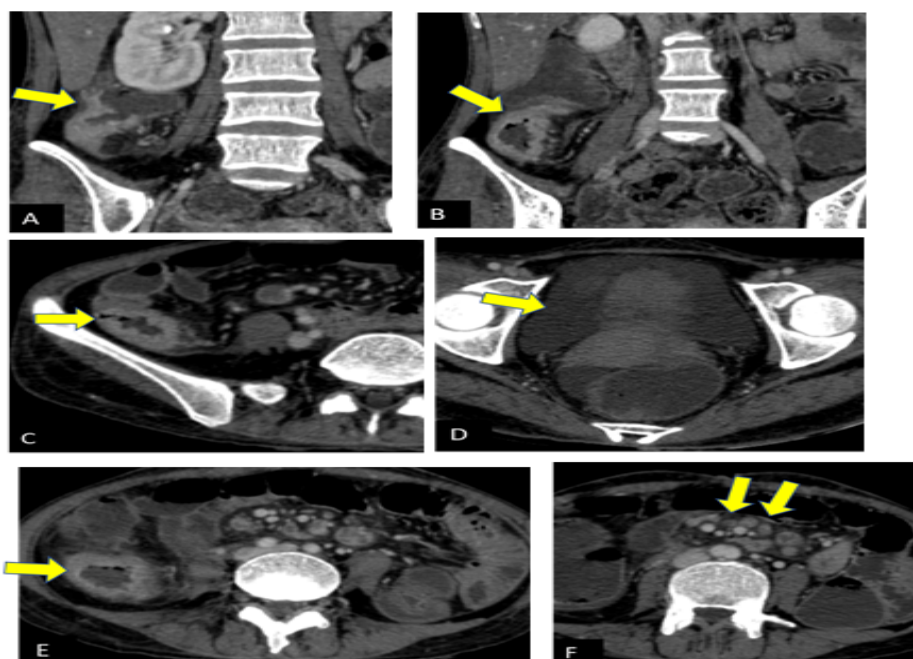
(A-C) CT coronal and axial showing diffuse wall thickening and enhancement of terminal ileum and caecum with surrounding fat stranding. Figure (D) Moderate ascites. Figure (E& F) Multiple necrotic mesenteric lymph nodes.
